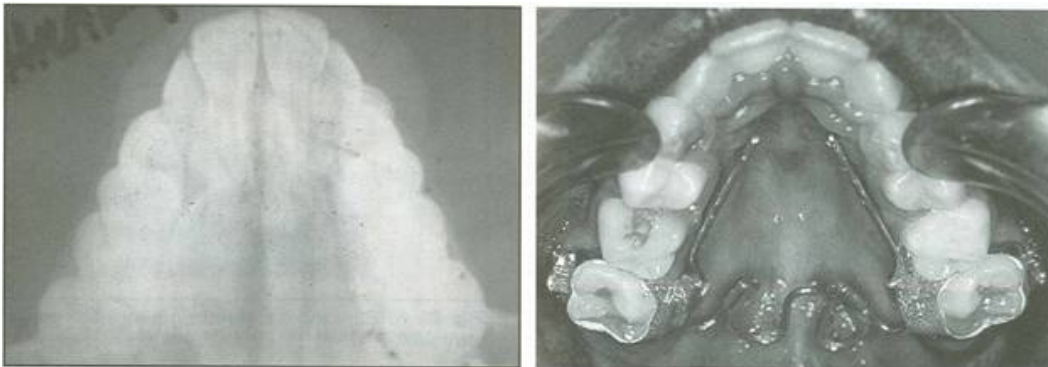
Case 2. Palatal x-ray and NPE2 at initial placement.
